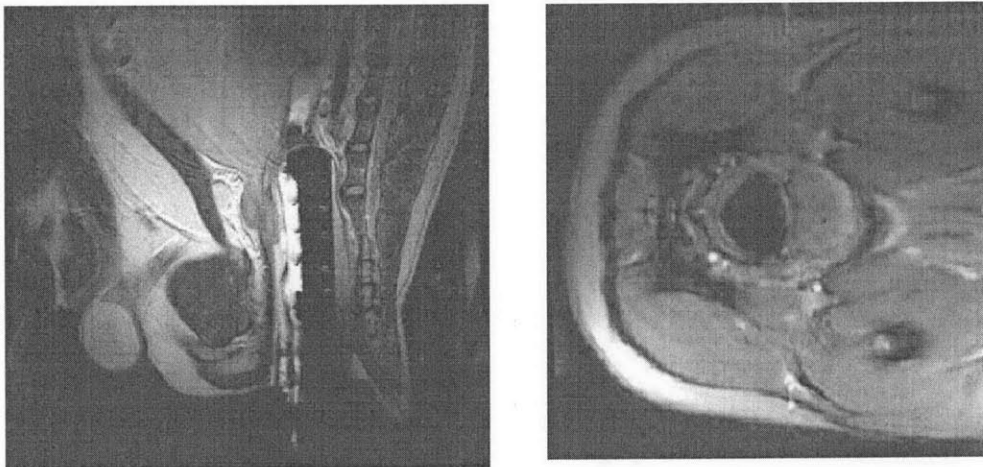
MR images of the transducer inserted into the rectum and positioned next to the prostate. A latex membrane surrounding the transducer is expanded using heated degassed water and covered with ultrasound gel to remove air pockets between the transducer and rectum. (a) Coronal image (fast spin echo T2 weighted image TR/TE 2000/75ms, echo train length 8, field of view 24 cm, number of excitations 2) (b) Axial image (the magnitude of fast spoiled gradient-echo imaging described in text).
